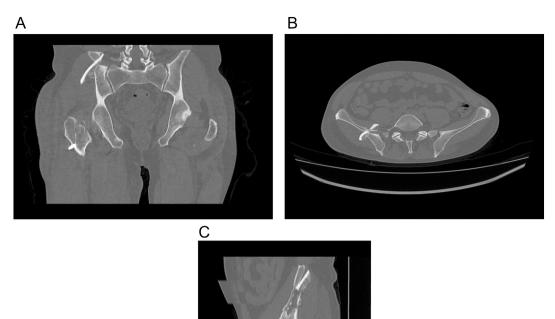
A, B and C – Coronal, axial and sagittal CT images of the pelvis. The images show a fracture of the right iliac wing, which was pierced by a cortical bone fragment.
